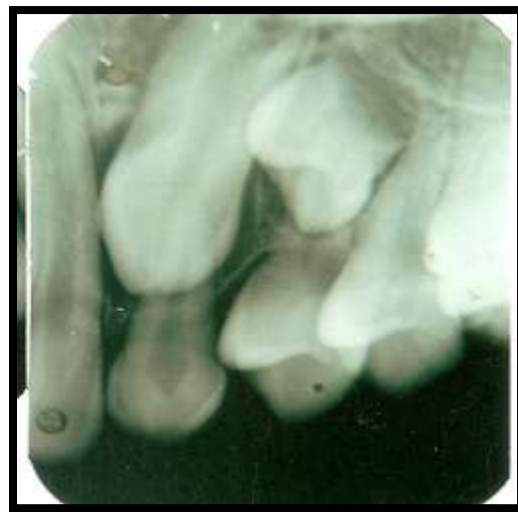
Intra-oral Periapical radiograph of 24, 25 region
